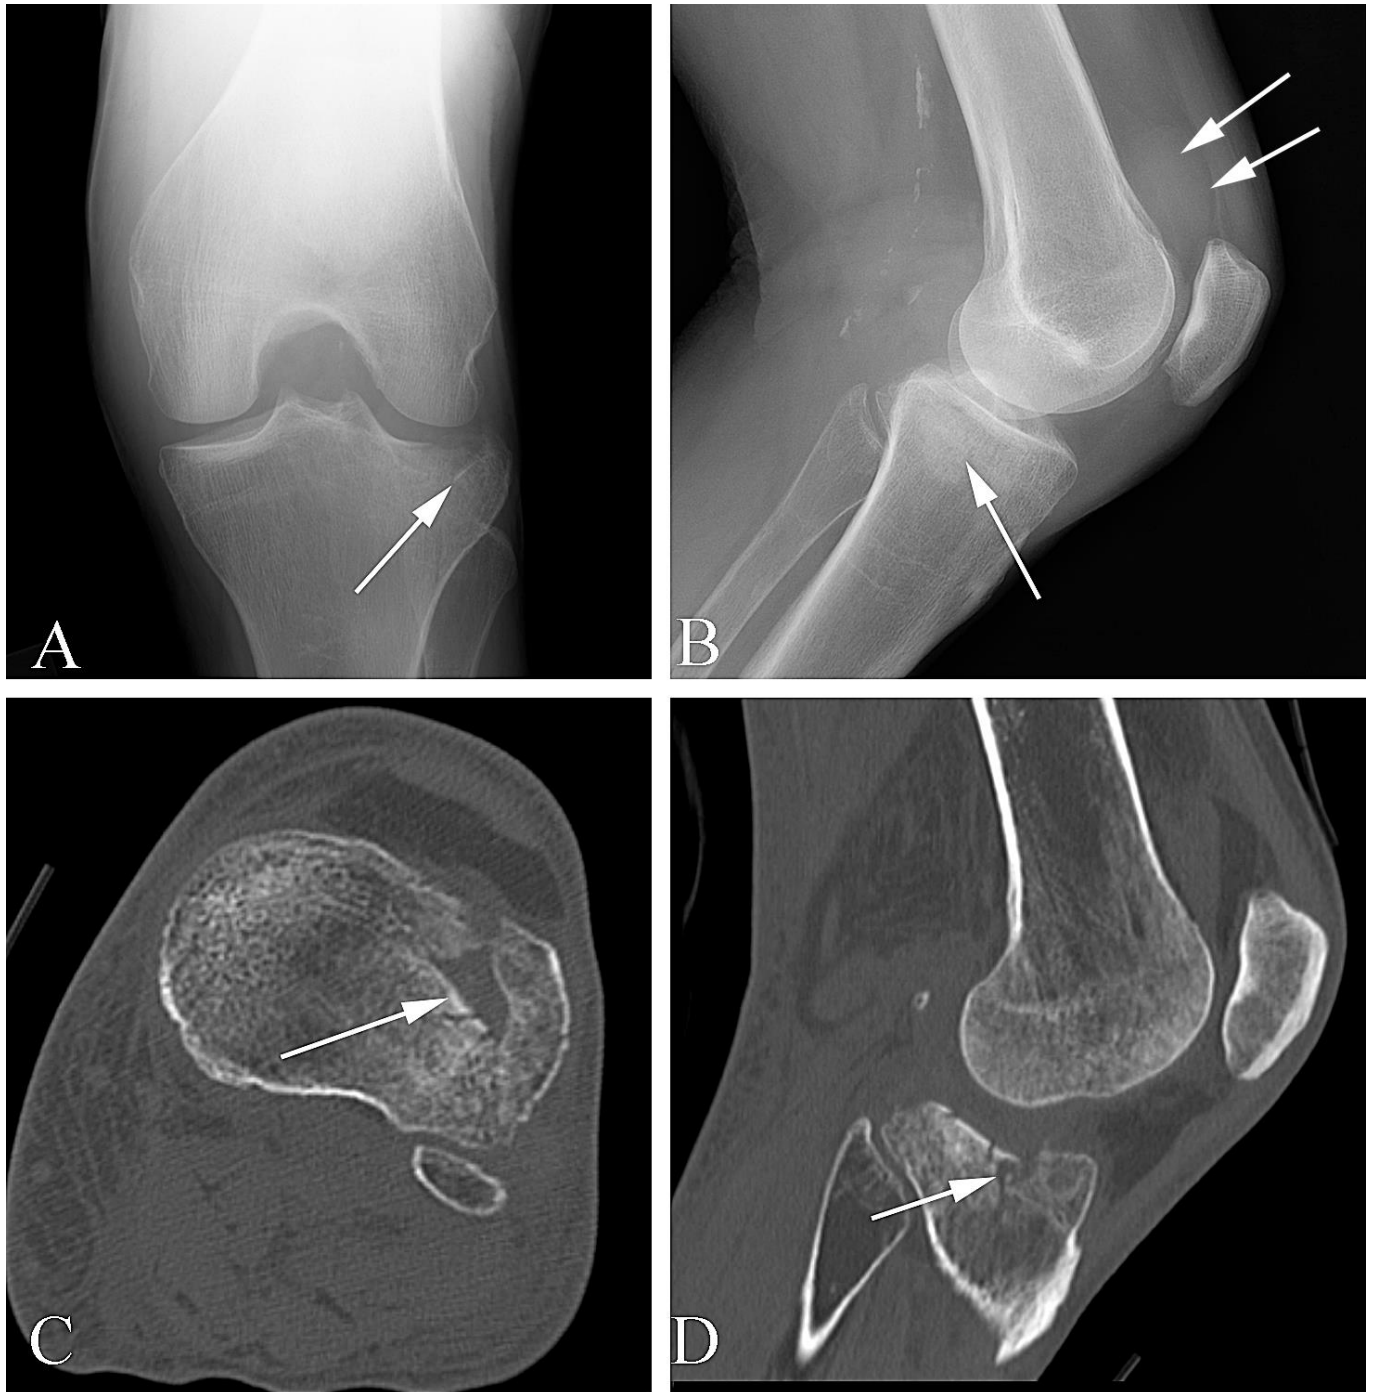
Tibial fracture in a 67 year old woman with knee pain following trauma. A. AP “notch” plain film of the knee shows a fracture along the lateral aspect of the tibial plateau (arrow). B. Lateral plain film of the knee shows an ill-defined density projecting at the level of the proximal tibia (arrow). Note the associated joint effusion superior to the patella (double arrow). C. Axial CT study shows a “hole” in the tibial plateau with rotation of the cortex out of its usual position (arrow). D. Sagittal reformatted CT study shows the tibial plateau fracture and documents the extent of depression and separation of fragments along the articular surface, as well as the number of fragments and their orientation (arrow).
